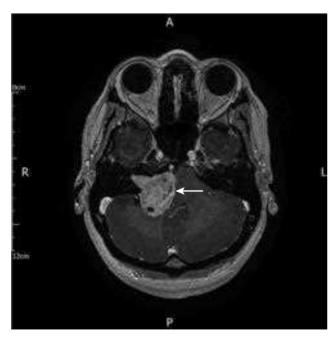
Axial gadolinium-enhanced T1-weighted MR image through the posterior fossa showing the typical 'ice-cream cone' configuration of a large right-sided vestibular schwannoma (arrow)
